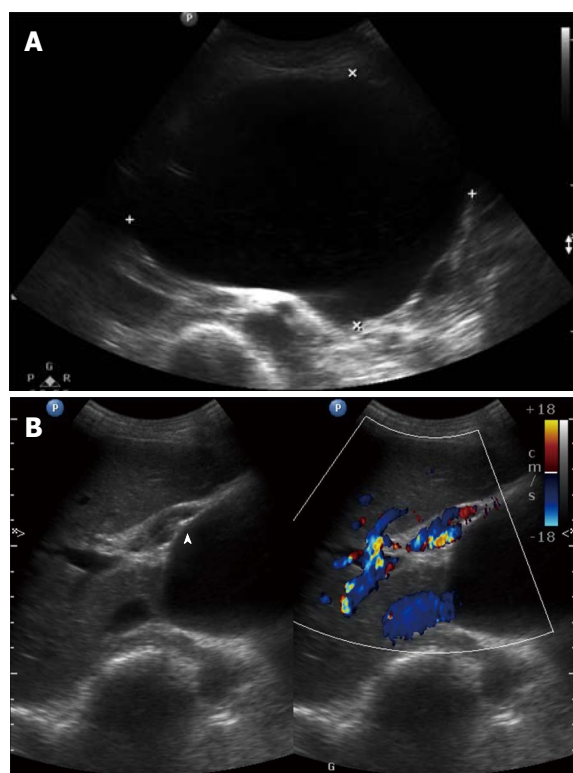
Ultrasound demonstrated a well-defined, lobulated cystic lesion with fluid debris at the pancreatic head. The size of the lesion is approximately 5.6 cm × 5.3 cm × 5.7 cm.
